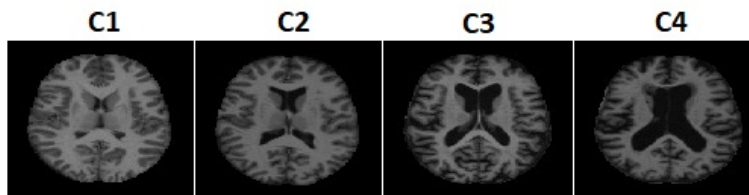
Sample images from each class of OASIS-MRI dataset.
